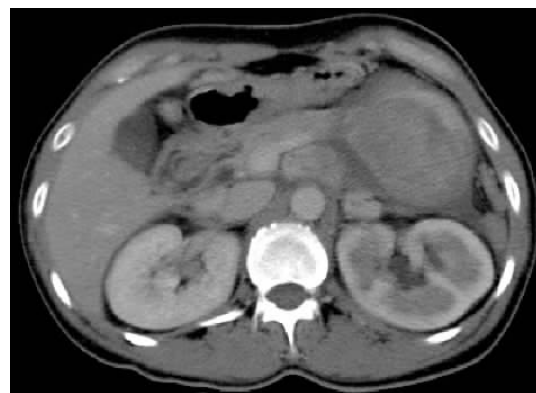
CT features of retroperitoneal GIST
